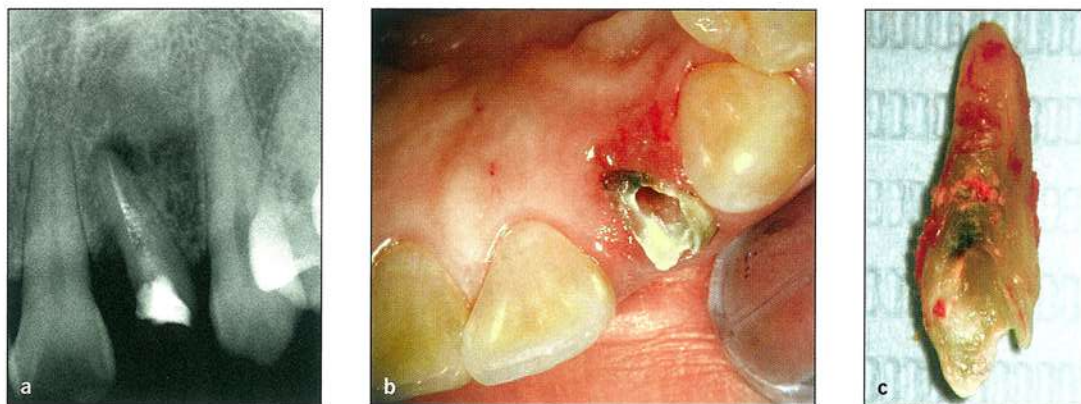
(a) Preoperative radiograph of a maxillary lateral incisor with inadequate root canal treatment and a periapical lesion. (b) A clinical image of the area shows the presence of inadequate tooth structure for placement of a crown and two adjacent teeth without restorations. (c) The tooth was extracted and replaced with a single implant.
